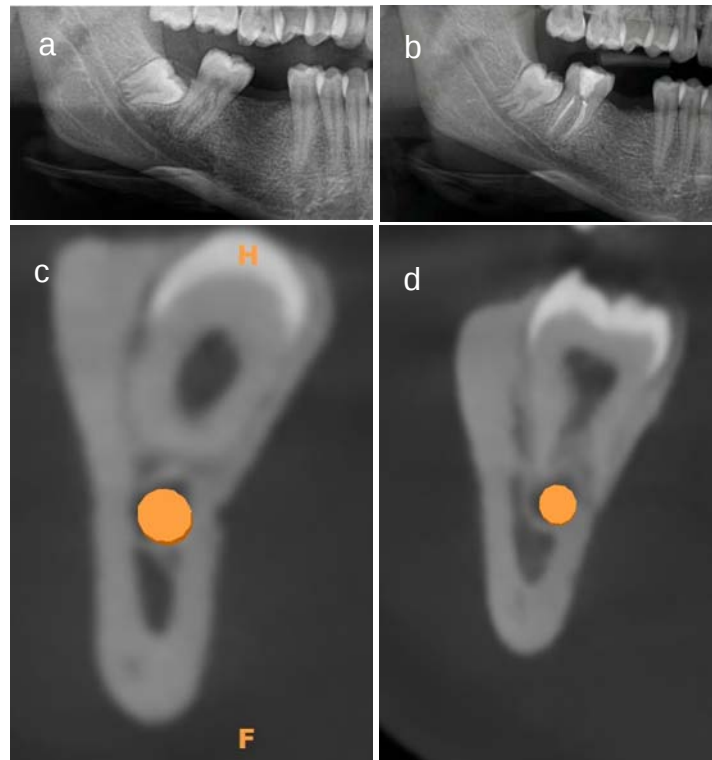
Orthopantomogram images depict an impacted mandibular lower third molar with incomplete (a) and complete root formation (b). Coronal sections of the CBCT images reveal a lack of contact between the canal and the tooth root during the initial phase of tooth development (c), but the roots are in close proximity to the canal following root formation (d).
